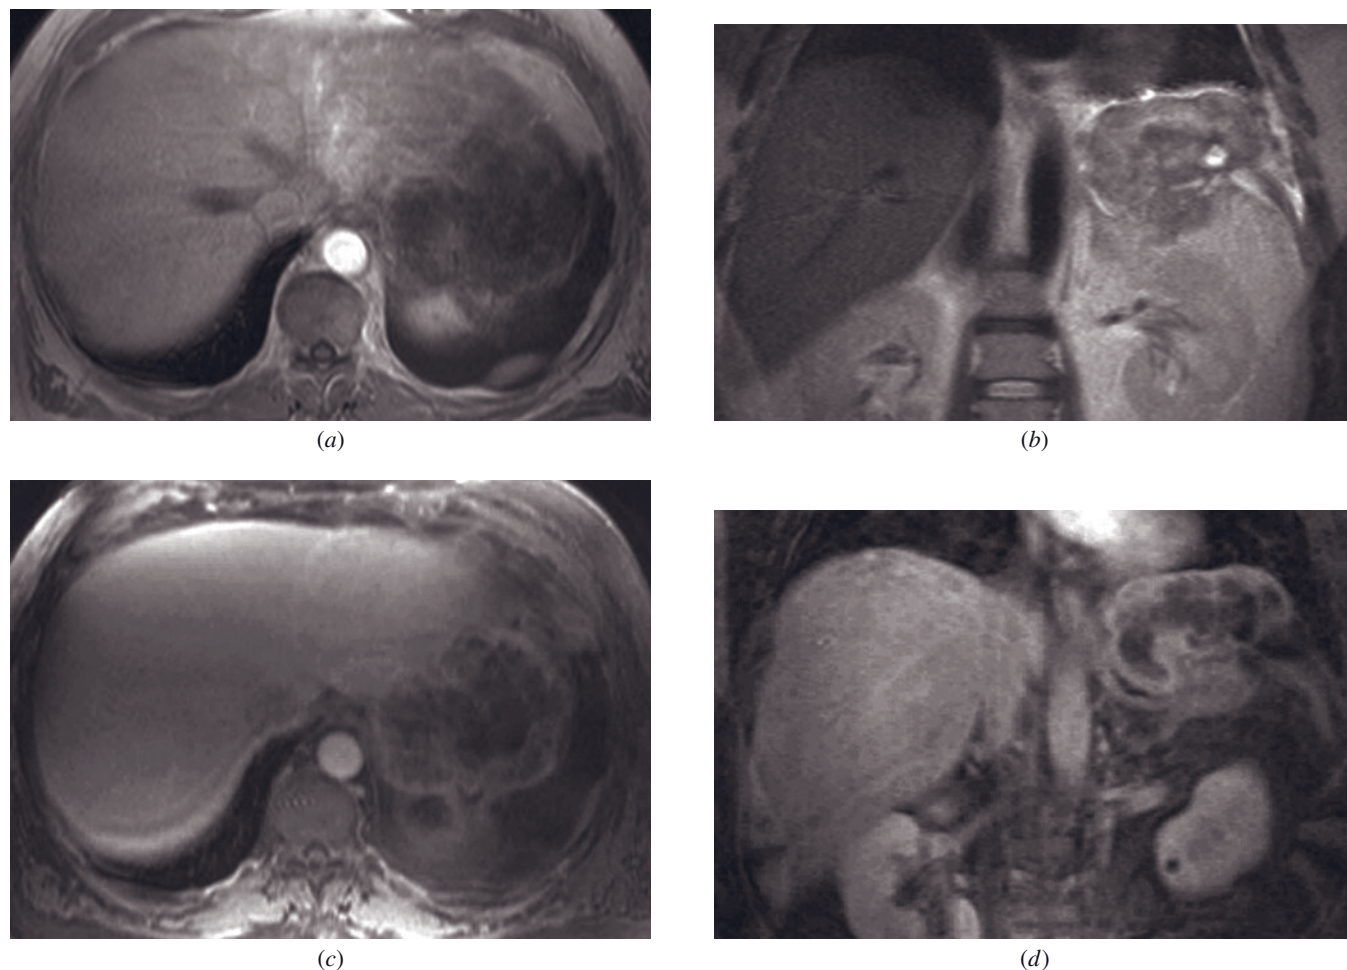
Angiosarcoma of the spleen. T1-weighted SGE (a), coronal T2-weighted single-shot echo-train spin-echo (b), immediate postgadolinium T1-weighted fat-suppressed 3D GRE (c), and delayed postgadolinium coronal T1-weighted fat-suppressed 3D GRE (d) images demonstrate a large splenic mass that is hypointense on T1-weighted image (a) and mildly high in signal intensity on T2-weighted image (b). The mass enhances heterogeneously on immediate postgadolinium images (c), and enhancement progresses on delayed images (d).
